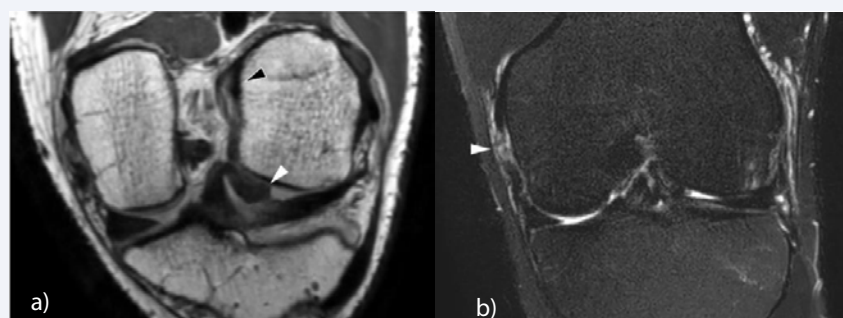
Associated injury of the medial collateral ligament. (A) Oblique coronal image shows complete detachment of the ACL from the femoral origin (black arrowhead) with the stump transposed beneath the lateral femoral condyle (white arrowhead). (B) Coronal fat-suppressed T2-weighted image shows a complete tear of the MCL (arrowhead).
